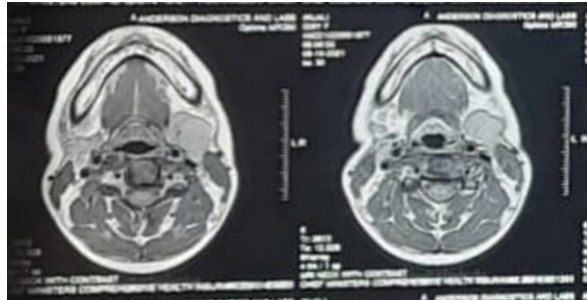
MRI Neck axial view showing hetero-intense left submandibular gland mass- suggestive of pleomorphic adenoma of left submandibular gland.
